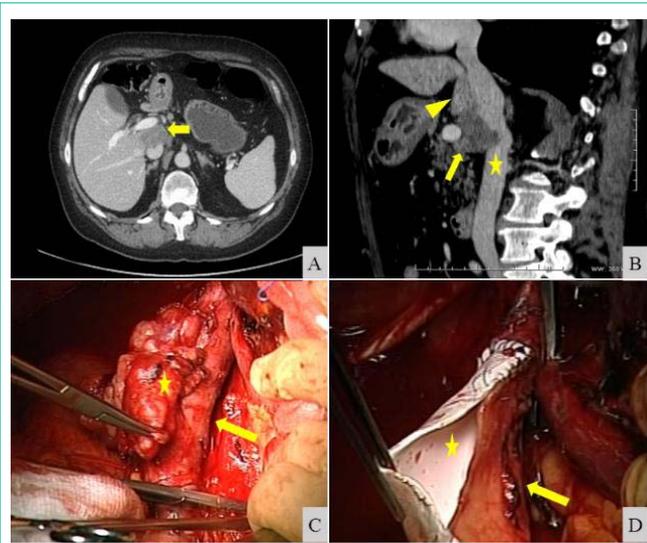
Clinical case #1: A) CT scan of soft tissue mass (arrow) of undetectable origin, adhering/infiltrating the caudate lobe of the liver, the inferior vena cava and the posterior wall of the portal vein; B) CT scan of soft tissue mass (arrow) between the inferior vena cava (star) and caudate lobe (arrow head); C) Intraoperative view of leiomyosarcoma (star) of inferior vena cava (arrow); D) Intraoperative view of inferior vena cava (arrow) reconstruction with a PTFE vascular prosthetic patch (star).
